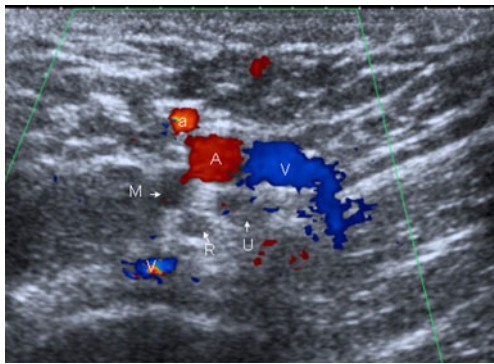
An accessory axillary artery (a) is detected on color Doppler imaging lateral to the axillary artery (A) coded in *red*. The axillary vein (V) was medial to the artery coded in *blue*. Duplication of the axillary artery caused a posteromedial shift in the position of the ulnar (U) and posterolateral shift in the position of median (M) nerve. The artery lies anterior to the median nerve. This posterior variant displacement is encountered in 1–5 % of patients
